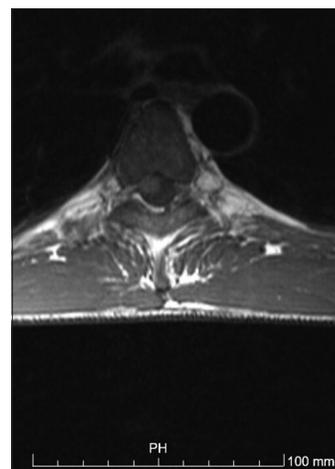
Non-contrasted T1 MRI showing spinal cord compression and anterolateral displacement.
